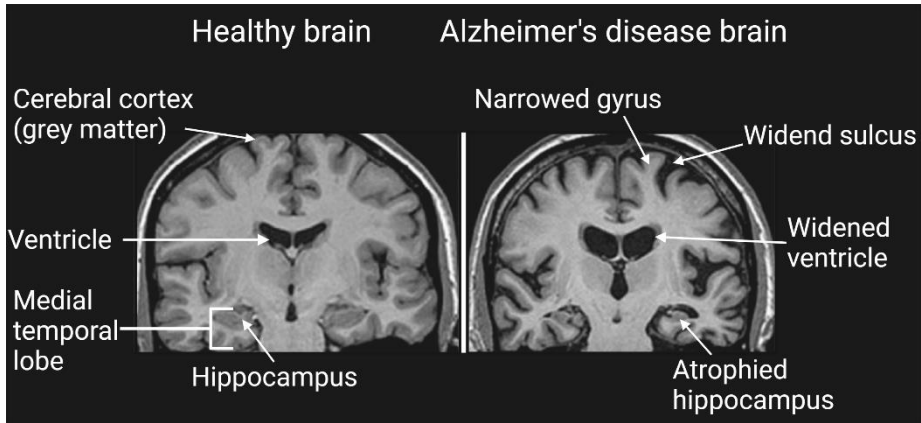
Magnetic resonance imaging (MRI)- derived coronal slices at the level of the medial temporal lobe in the healthy brain (left) and Alzheimer's disease brain (AD) (right). The image depicts characteristic changes of hippocampal volume loss, widened ventricles and sulci and narrowed gyri due to neurodegeneration and loss of gray matter in AD. Created with BioRender.com.
